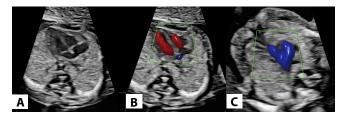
Axial images of fetal heart from a 13 weeks fetus (transvaginal ultrasound). A.4-chamber view on gray-scale. B.4-chamber view with color doppler showing two AV stripes C. Three-vessel-trachea view on color Doppler showing a V-shape, equal sized vessels and same direction of flow.
